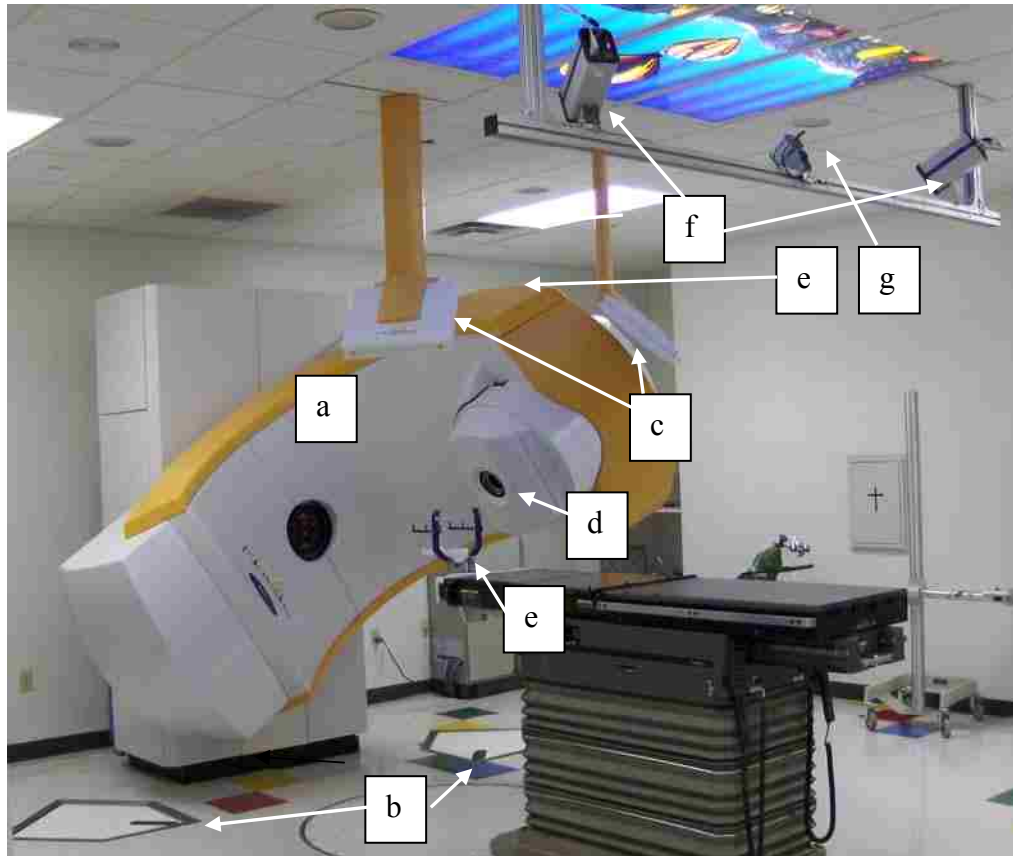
BrainLAB Treatment Room: (a) BrainLAB Novalis 6MV Linac; (b) X-ray Tubes; (c) aSi Flat Panel Detectors; (d) BrainLAB m3 MicroMLC; (e) SRT U-frame: supports BrainLAB mask immobilization system; (f) Infrared Camera System; (g) Video Camera System; (h) Room Coordinate System (IEC convention 61217); (i) BrainLAB Couch Mount.
